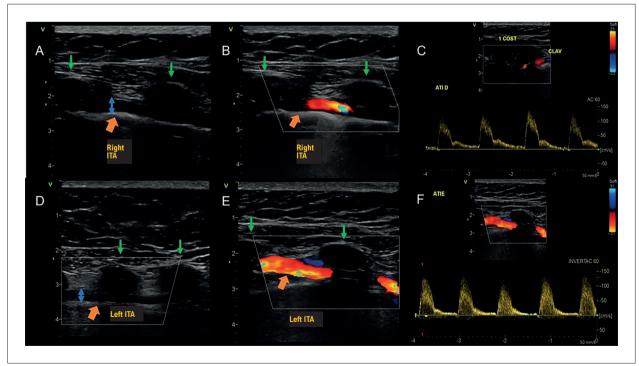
A and D) right and left ITAs, seen on bidimensional ultrasound; B and E) flow in the right and left ITA at color Doppler; C and F) flow in the ITAs at spectral Doppler. Orange arrows: identify ITAs on ultrasound. Blue arrows: measurement of the diameter of the right (3.6mm) and left (3.3mm) ITA. Green arrows: ribs.
